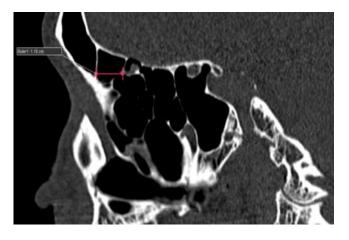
Sagittal CT showing distance between AEA and posterior wall of frontal sinus ostium.
